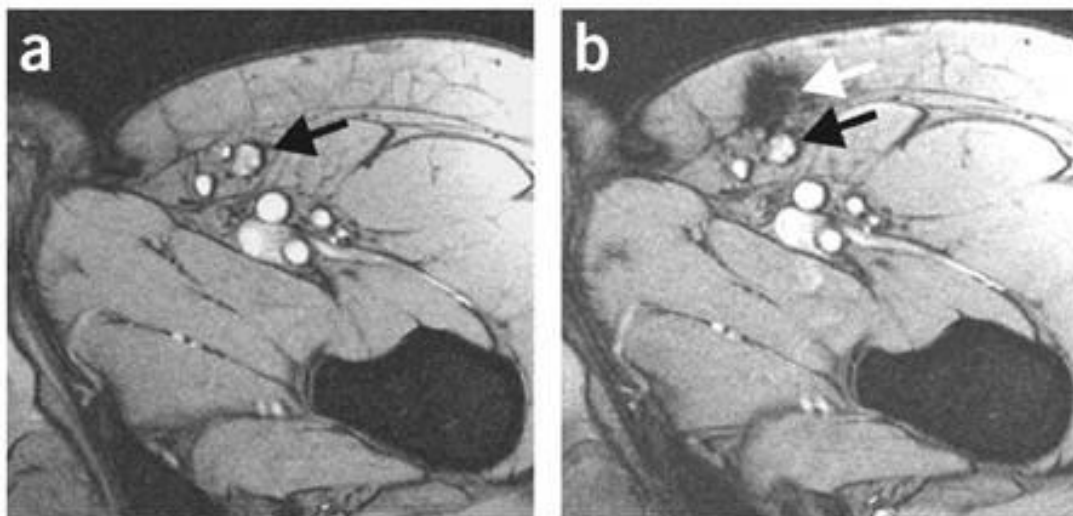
(A) T2*-weighted MRI (3T) before cell administration; the inguinal lymph node to be injected is indicated with a black arrow and (B) after injection showing that the dendritic cells were not accurately delivered into the inguinal lymph node (black arrow) but in the vicinity, i.e. the subcutaneous fat (white arrow). Acquisition parameters: average echo time of 15 ms (flip angle 36°, repetition time (TR) 1,060 ms, total acquisition time ~9 min, 30 slices, resolution 0.50 × 0.50 × 3.50 mm). Figure was copied from de Vries et al. [114].
